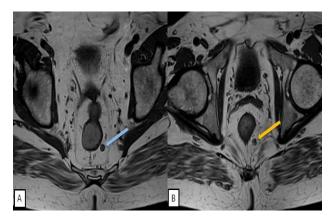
(A and B): MRI showing two hypointense round lymph nodes in the mesorectum (blue and yellow arrows).
